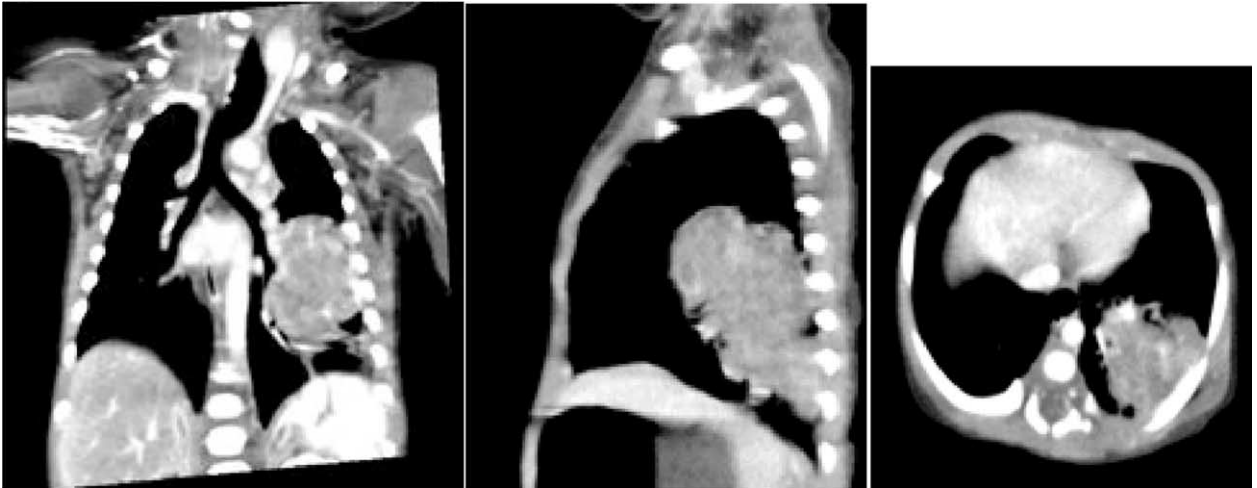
Computed tomography scanning revealed an iso- or hypo-dense mass located in left lower lung. The tumor had irregular margin and ground-glass opacification surrounded. After contrast administration, the tumor had heterogeneous enhancement.
